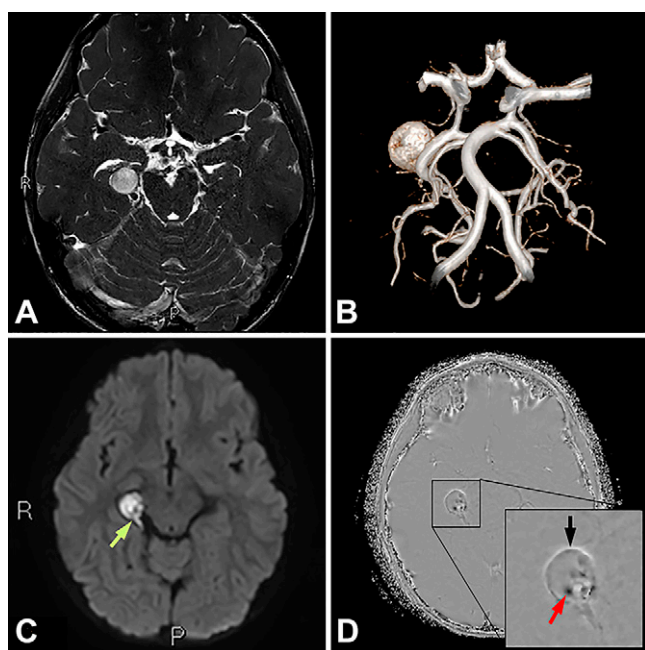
Preoperative T2-weighted magnetic resonance imaging (A) showing a hyperintense $14 \times 14 \times 15$ -mm circular lesion within the right ambient cistern. Preoperative three-dimensional magnetic resonance angiography (B) demonstrating the lesion adjacent to the right posterior cerebral artery (PCA), suggestive of a cerebral aneurysm. Axial diffusion-weighted image (C) demonstrates diffusion restriction with possible connection to the adjacent PCA (green arrow). Axial susceptibility-weighted, filtered-phase image (D) showing a hyperintense rim of calcification surrounding the lesion (black arrow). Dark foci of hemosiderin blood products (red arrow) and adjacent bright foci calcium are visible within the lesion.
